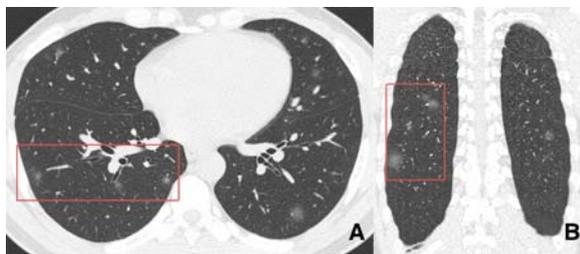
CT images (A-axial, B-coronal) of a 30-year-old male with COVID-19. Notice the well-defined ground glass nodules in both the lungs with some halo around some of the nodules (red box).
